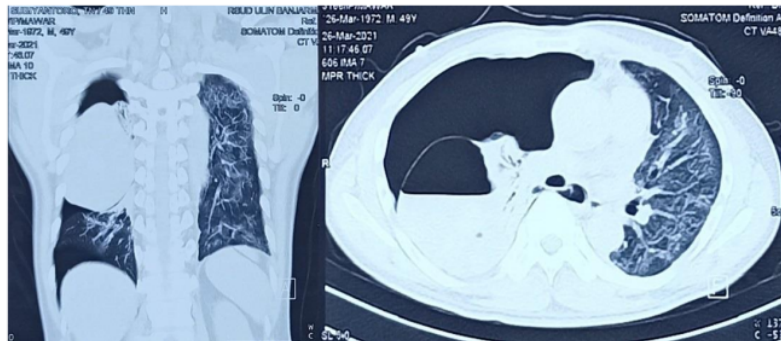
Chest CT scan showed right pneumothorax, Post covid pulmonary fibrosis, infected giant bullae subpleura right perihilar, accompanied by right lung collapse and minimal right to left lung herniation. No left intrapulmonary bullae seen
